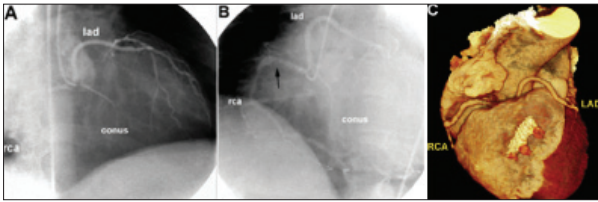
Coronary angiography (A, B) and multislice computed tomography (C) views of coronary arteries arising from the right aortic sinus with separate ostia
